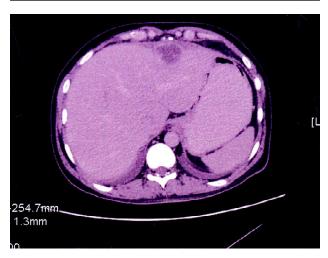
Axial CT scan through the level of liver reveals a thick-walled aboves in relation to the left liber of liver.
